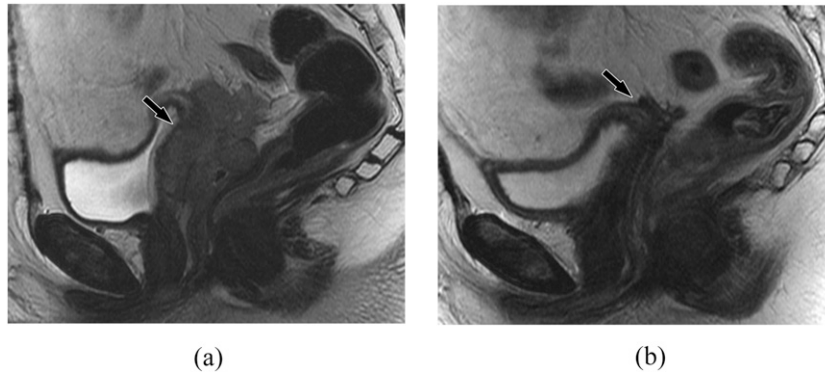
A 47-year-old female with a history of vaginal intraepithelial neoplasia, status after upper vaginectomy with recurrent vaginal mass 15 months later. (a) Sagittal T_2 weighted MR image shows a mass involving the vaginal cuff and upper half of the remaining vagina (arrow). Biopsy confirmed squamous cell carcinoma. (b) Sagittal T_2 weighted MR image following treatment with chemoradiation shows resolution of the vaginal mass. Mild residual very low T_2 signal (arrow) is compatible with fibrosis.
